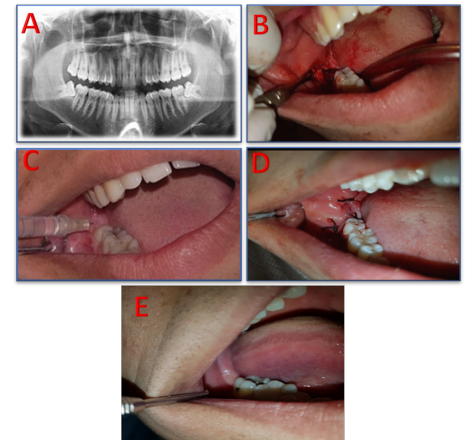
(A) Panoramic radiograph. (B) Tooth removal. (C) Submucosal injection of dexamethasone. (D) Suturing. (E) Suture removal.
